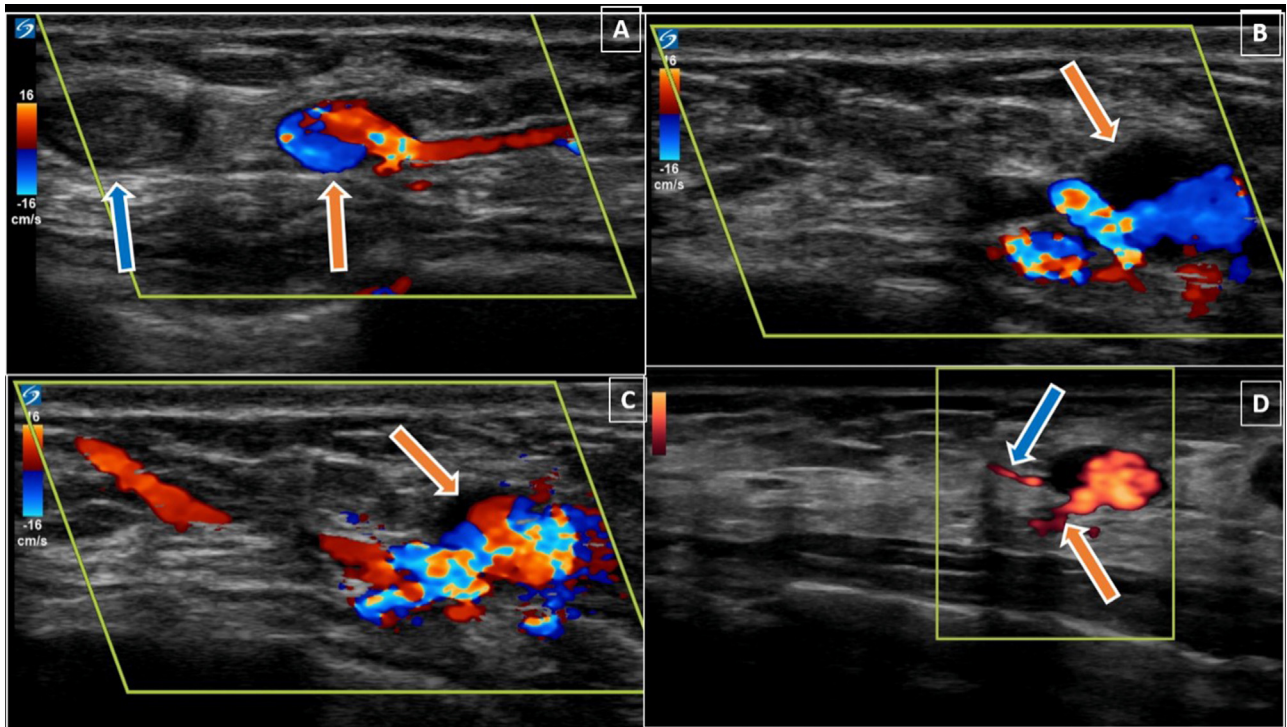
Multiple sonographic images demonstrate pseudoaneurysms. There is characteristic “yin-yang” sign within one of the pseudoaneurysms (orange arrows in images A, B, C). There are at least 1 or 2 feeding vessels within that pseudoaneurysm (blue and orange arrows in image D), indicative of patency. Adjacent to the patent pseudoaneurysm (orange arrow in image A), there is a second pseudoaneurysm with no flow, indicative of spontaneous thrombosis (blue arrow in image A).
